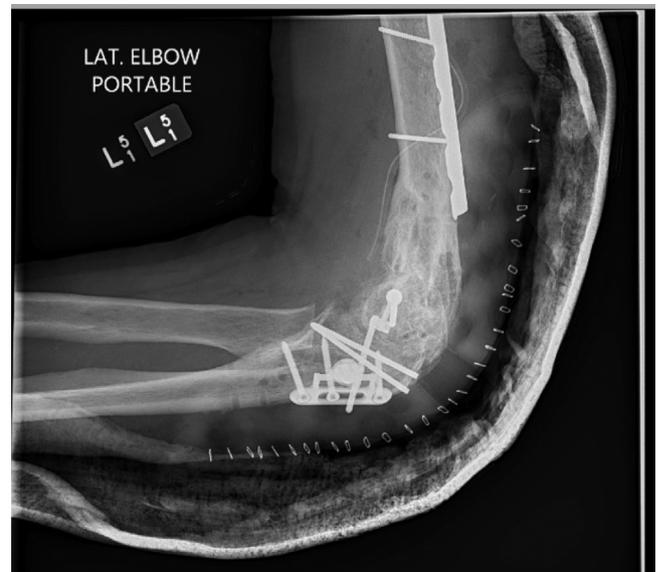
Postoperative radiographs of 38-year-old patient undergoing hardware removal, kashiwagi-outerbridge, joint capsule debridement, internal joint stabilizer, and radial head excision. Intra-operatively the decision was made to remove only the symptomatic portion of the humeral plate to reduce anatomic dissection.
